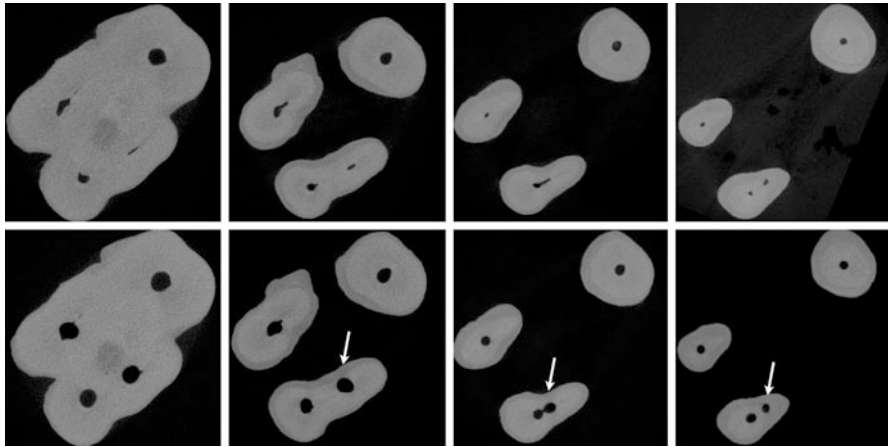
Cross-sectional micro-computed tomography images of an extracted first maxillary molar before (*upper panel*) and after (*lower panel*) preparation with rotary instruments on four different root levels. Note the shape of the mesiobuccal root and limited radicular wall thickness before and after preparation (*arrows*)
